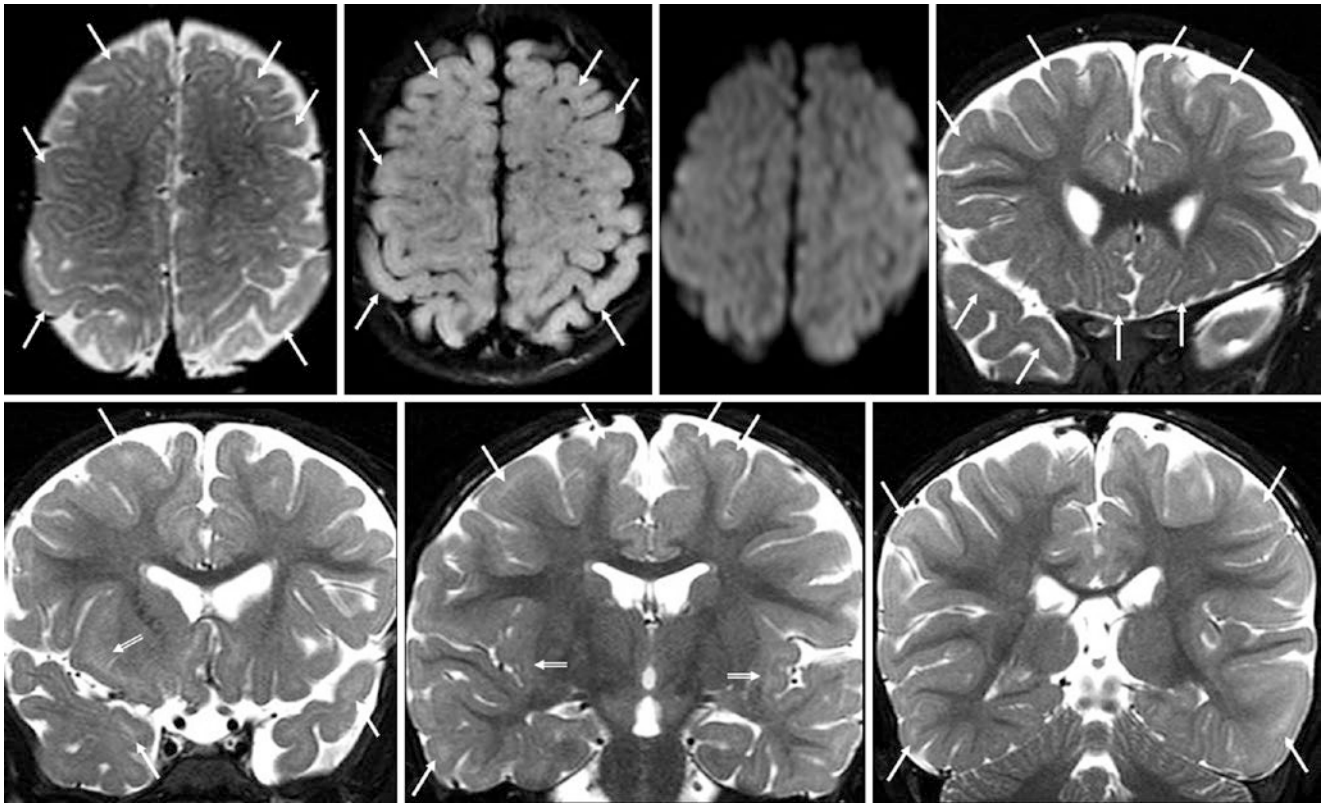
“Patchy” SCWM in a 16.5-month-old with seizures on a 1.5T MRI. The myelination pattern was normal, but with patchy SCWM (*thin arrows*) that is most visible within the anterior and inferior frontal and temporal lobes, as well as within the SIWM (*beveled arrows*), on axial SE T2WI (*top left*). The SCWM foci are not well visualized on
